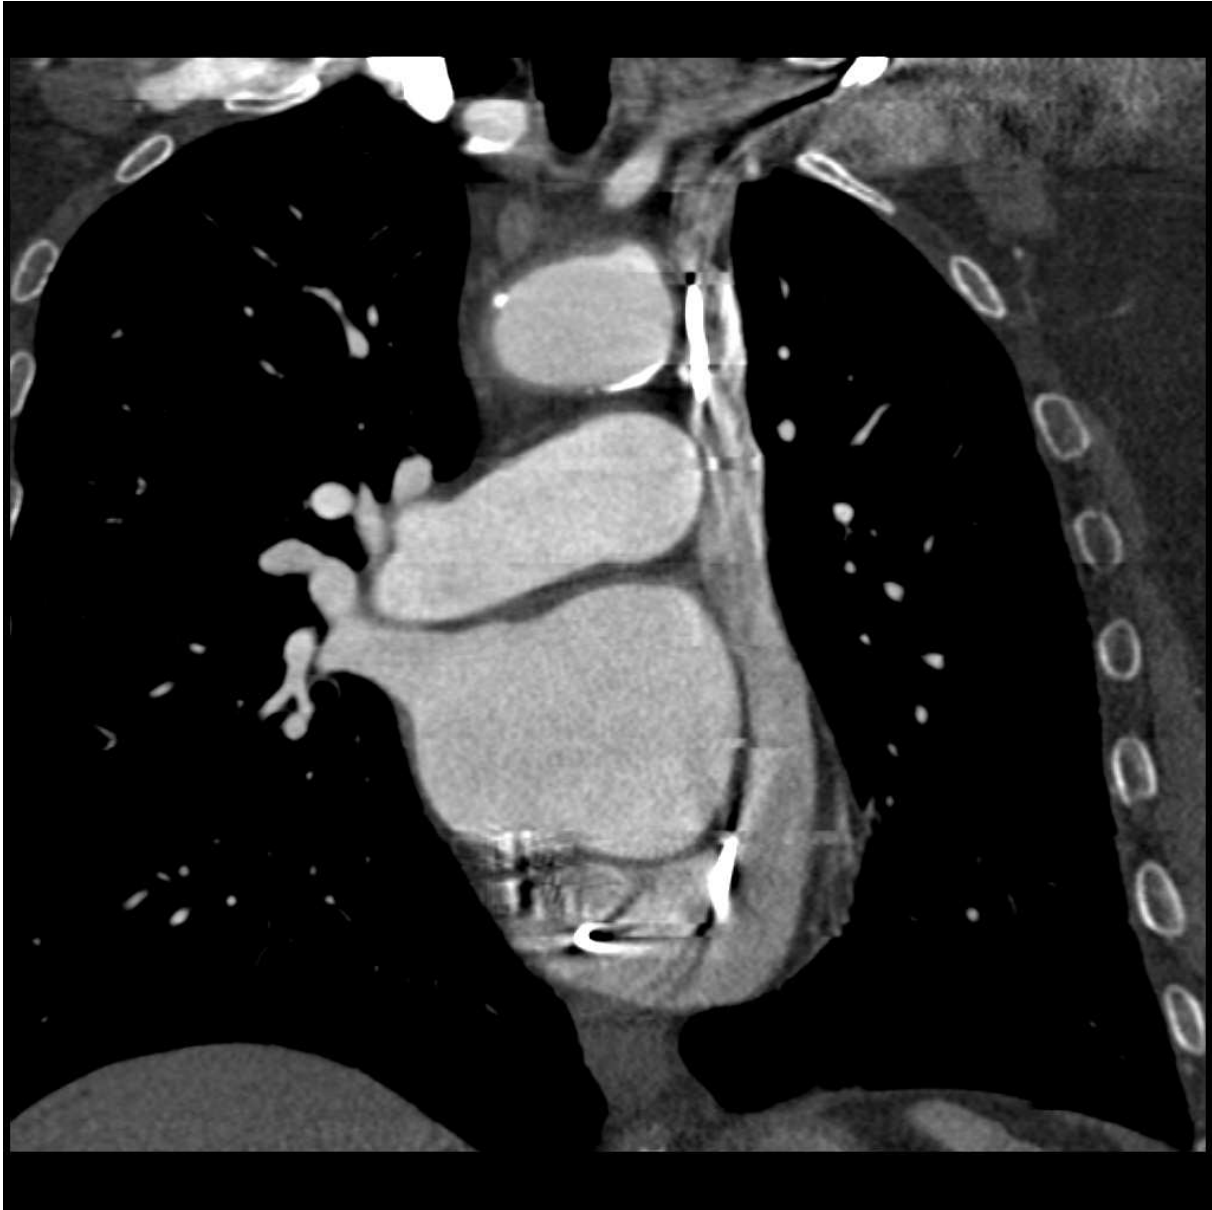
Curved multiplanar reformation, CT. Pacemaker electrodes passing through single PLSVC into coronary sinus.
